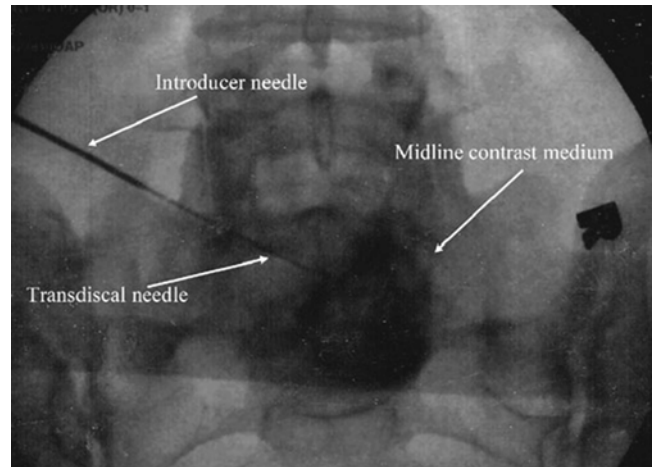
AP radiographic view of transdiscal contrast medium
